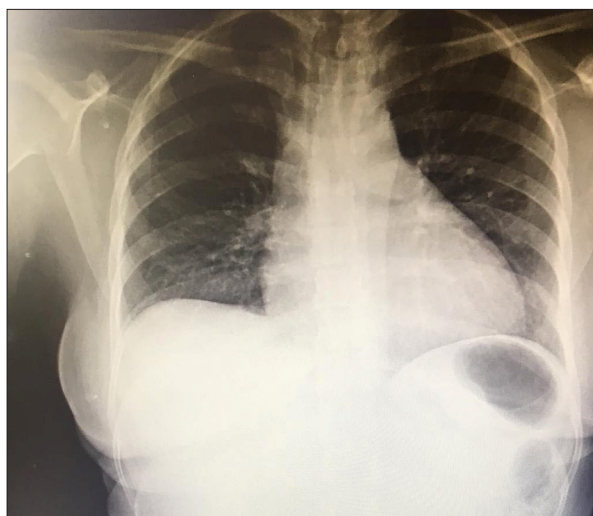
Chest X-ray at the time of admission showing borderline cardiomegaly with clear lung fields.
